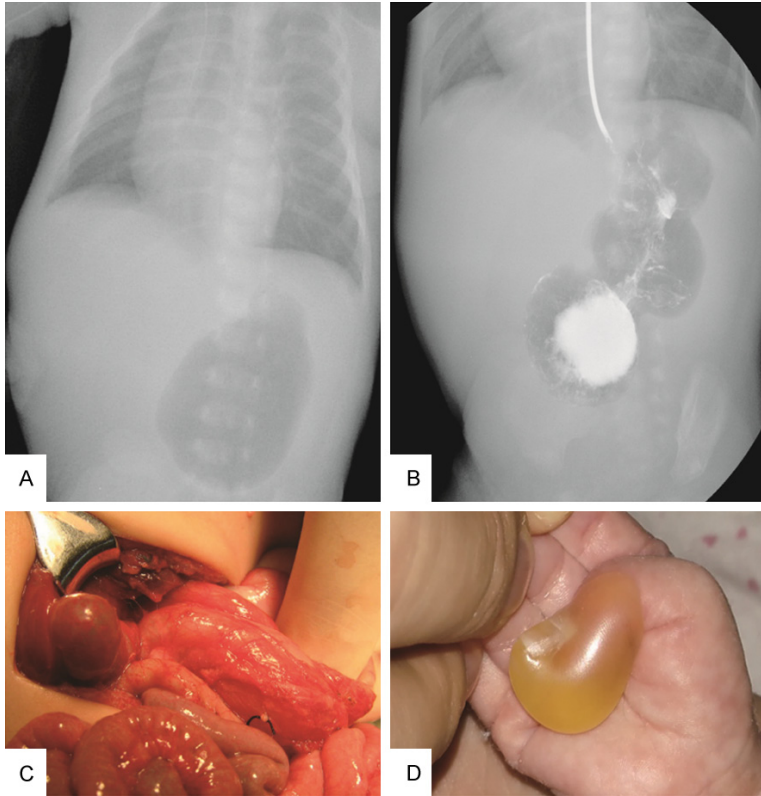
Clinical presentation of EB-PA patient. A. A plain abdominal X-ray showing a single large gastric gas bubble, with no air distal to pylorus. B. Upper GI series with Gastrografin show a 'single bubble sign' representing pyloric obstruction. C. Intra-operative image of fibrous pyloric cord. D. A blister that appeared on the infant's hand.
